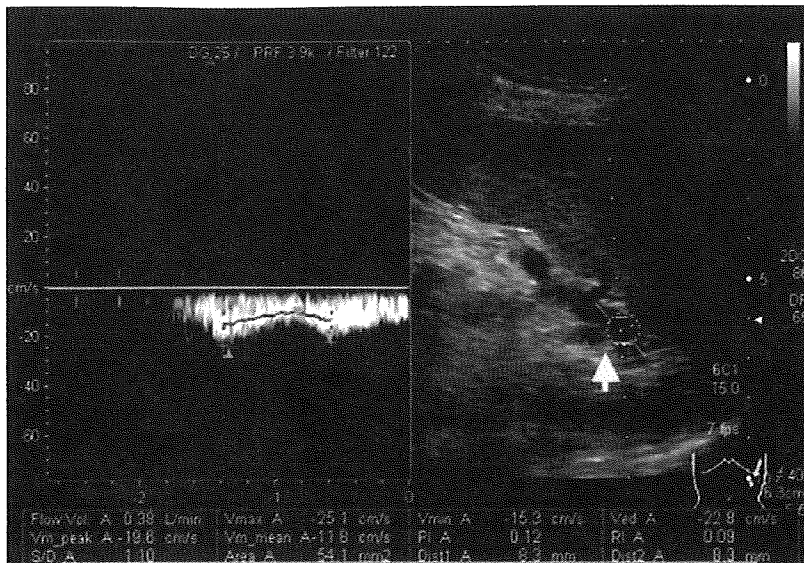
Doppler ultrasound of patients with gastric fundal varices. The sonogram under the left intercostal scan demonstrated the short gastric vein (SGV) with flow in the hepatofugal direction (arrow).
